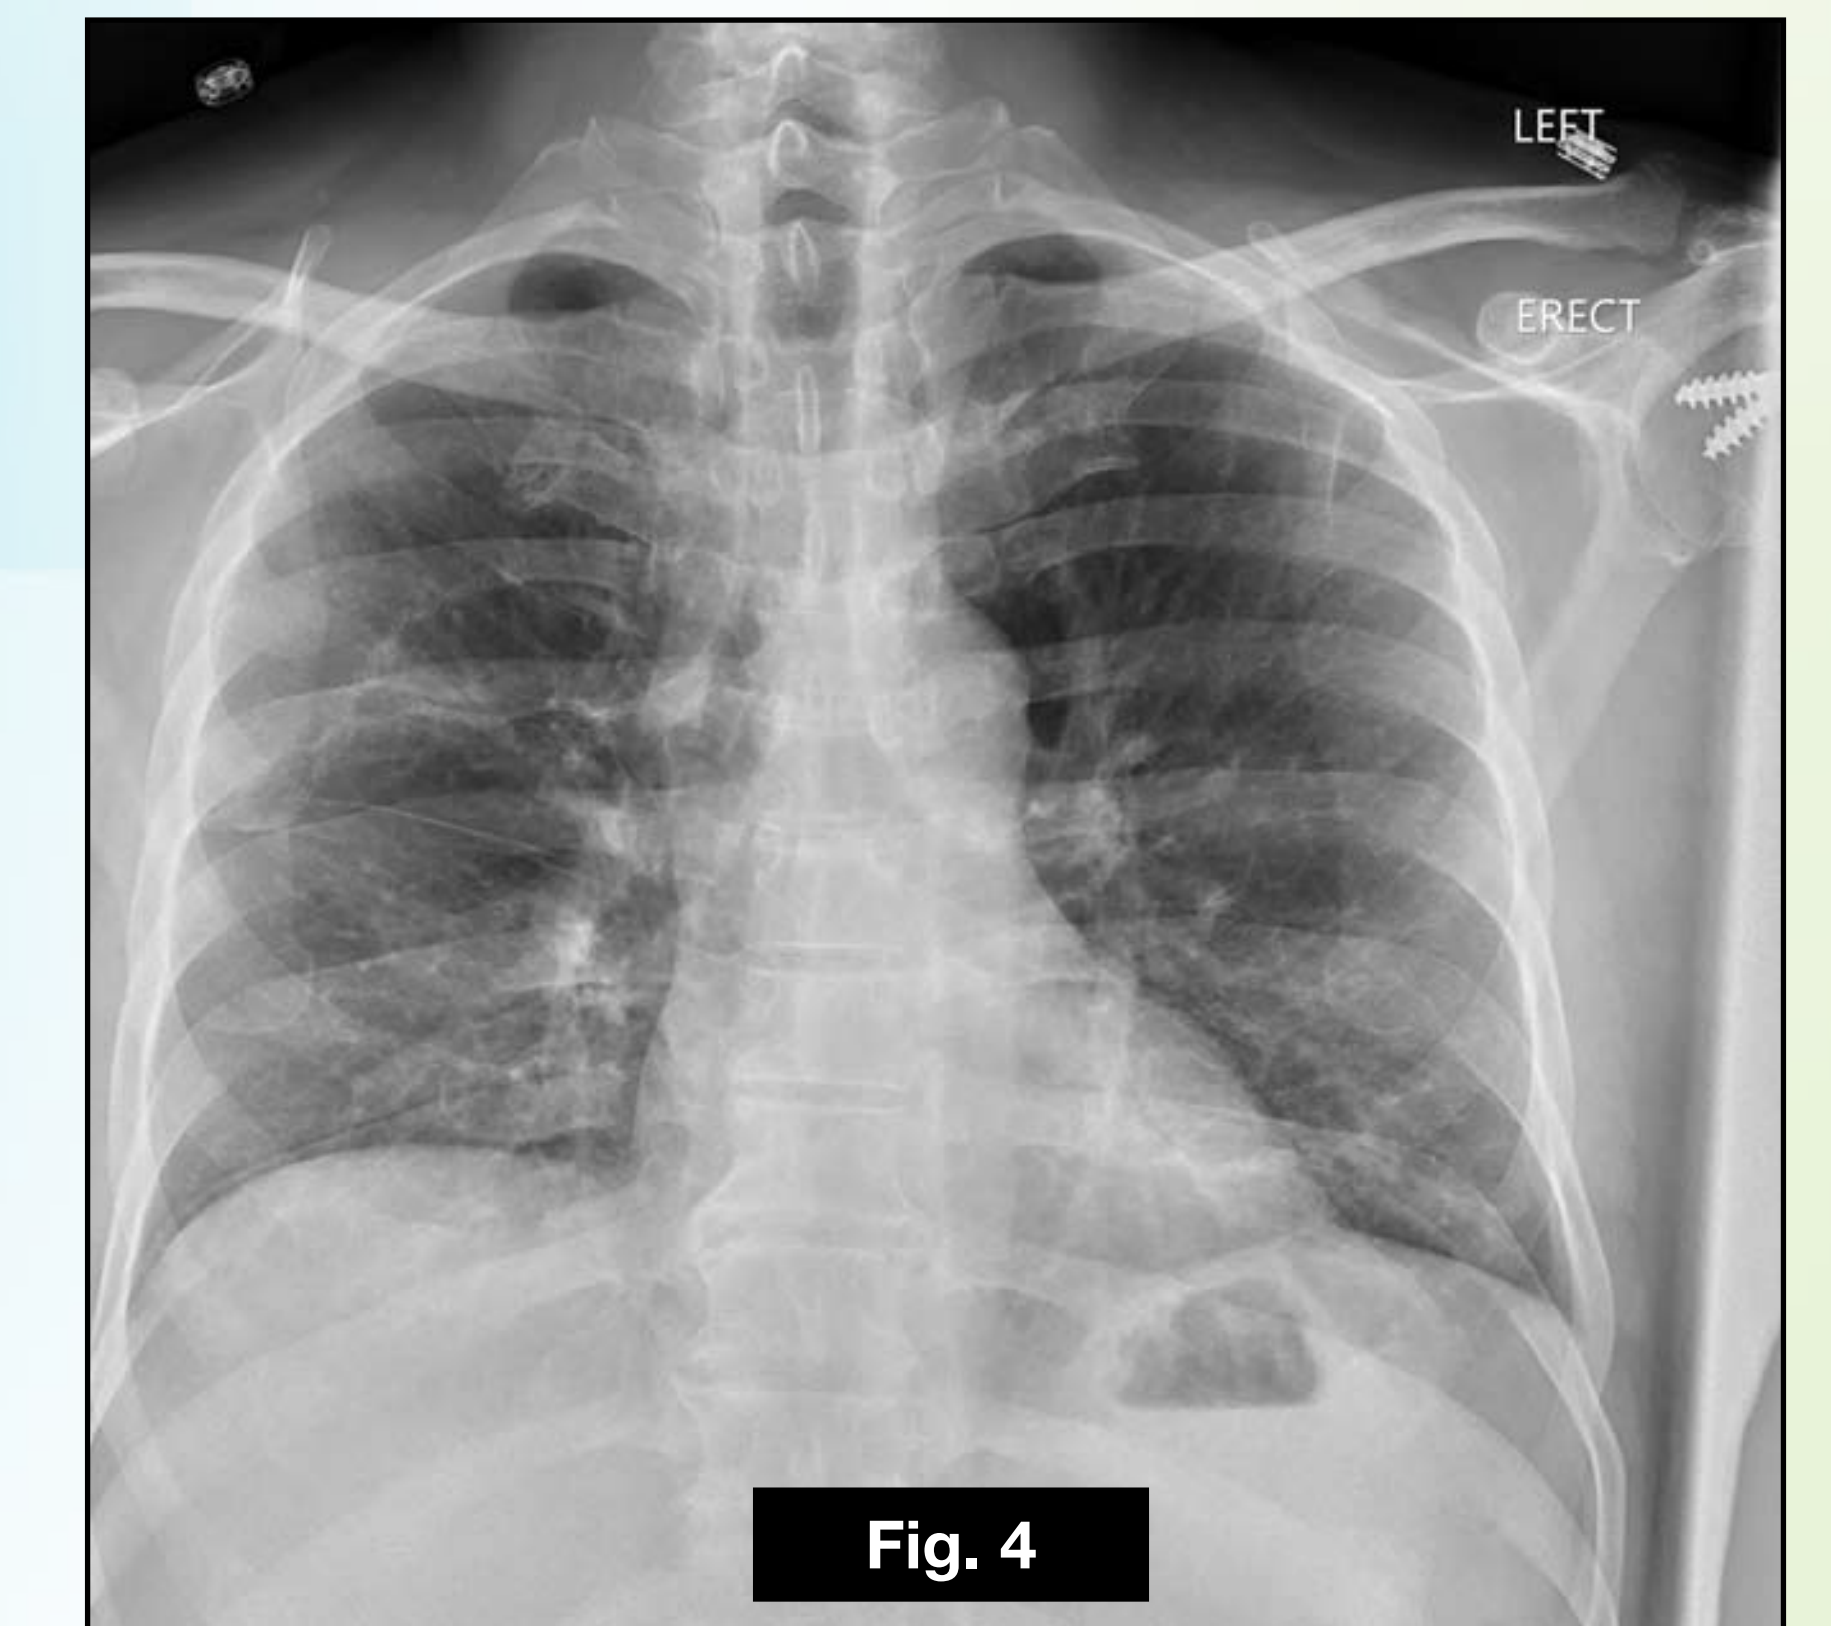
Chest X-ray showing improvement of bibasilar interstitial infiltrates after 12 weeks.
